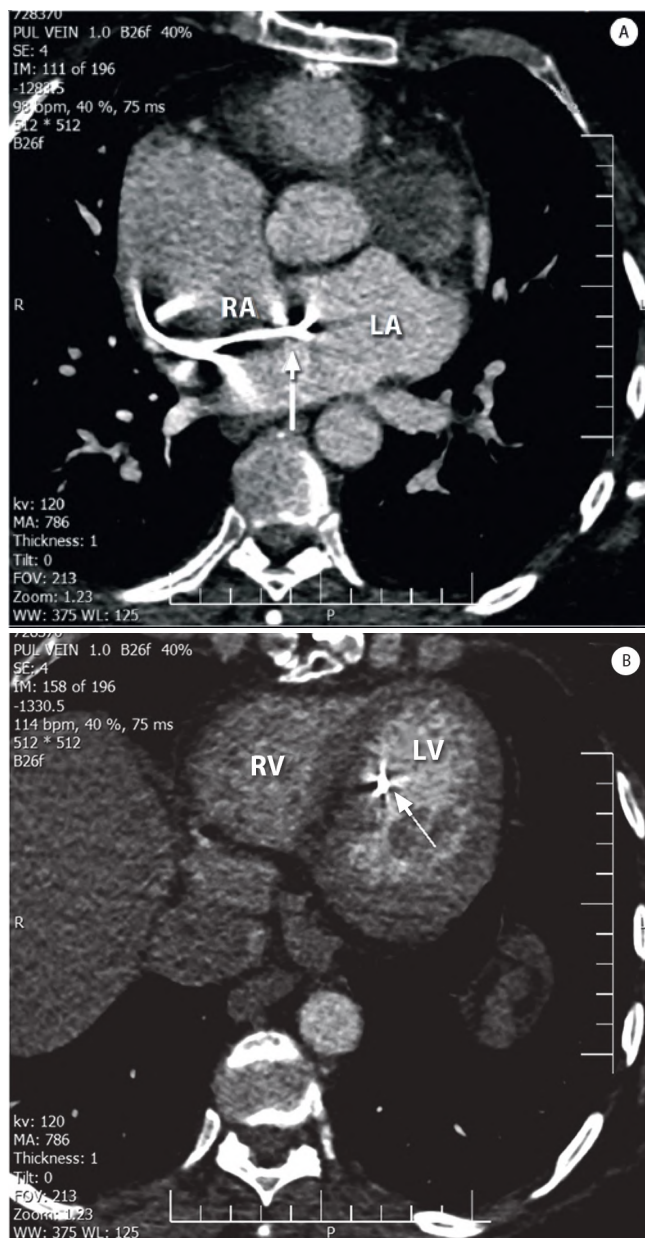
Cardiac computed tomography shows A) the passage of the pacing wire (arrow) through the interatrial septum into the left atrium and then B) into the left ventricle near the septum (arrow).
